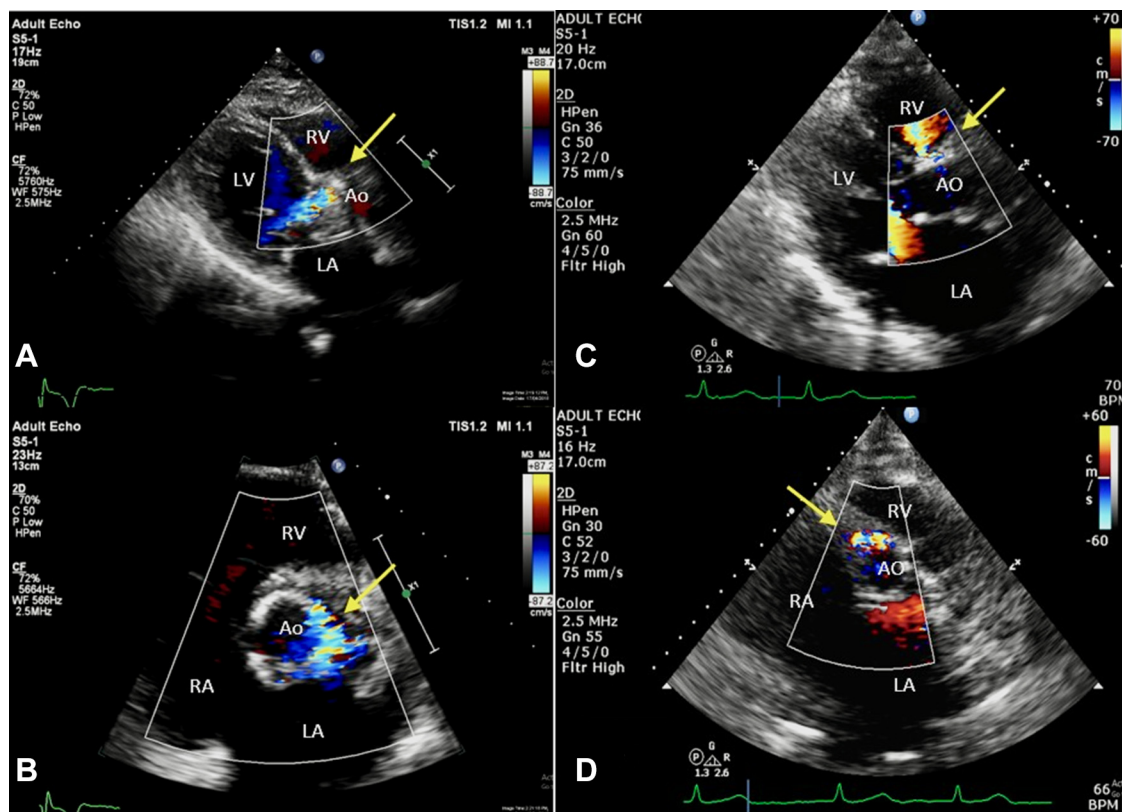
Two-dimensional TTE parasternal long-axis and parasternal short-axis (*bottom*) views with color flow Doppler in a patient post-TAVI with a PVL (A, B; arrows) compared to this reported patient with an ARV fistula (C, D; arrows). Ao, Aorta; LA, left atrium; RA, right atrium.
